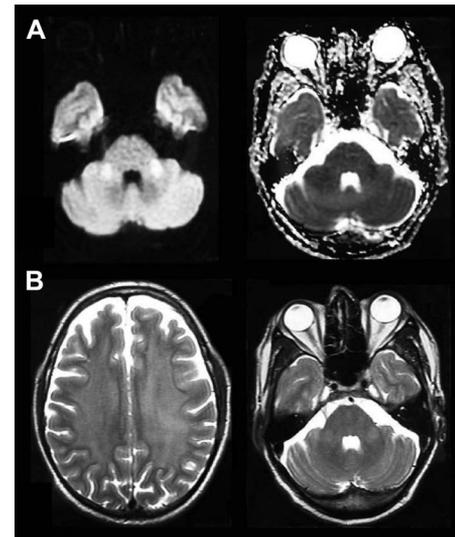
Cranial MRI (A) diffusion restriction involving bilateral middle cerebellar peduncles and (B) T2 hyperintensities in bilateral periventricular and deep white matter and middle cerebellar peduncles
